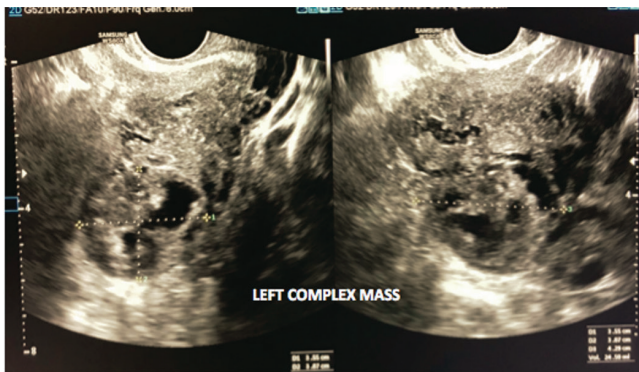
Initial transvaginal ultrasound showing a complex mass 3.55 cm x 3.07 cm x 4.29 cm (vol 24.50mL) medial to the left ovary which seems adherent to the left side of the uterus
